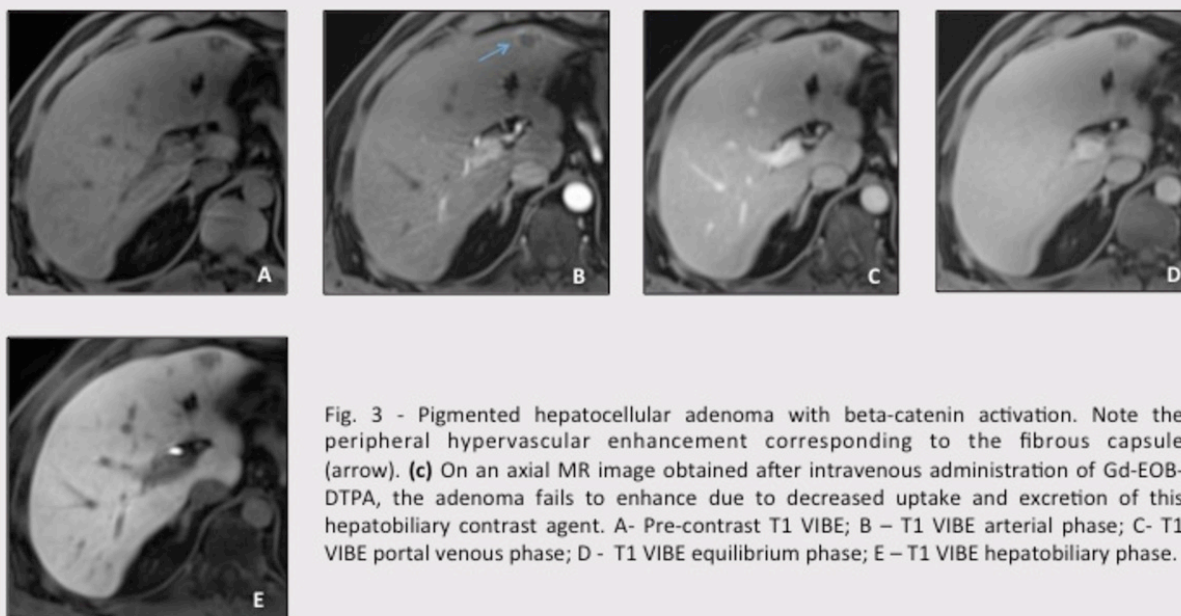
Pigmented hepatocellular adenoma with beta-catenin activation. Note the peripheral hypervascular enhancement corresponding to the fibrous capsule (arrow). (c) On an axial MR image obtained after intravenous administration of Gd-EOB-DTPA, the adenoma fails to enhance due to decreased uptake and excretion of this hepatobiliary contrast agent. A- Pre-contrast T1 VIBE; B - T1 VIBE arterial phase; C- T1 VIBE portal venous phase; D - T1 VIBE equilibrium phase; E - T1 VIBE hepatobiliary phase.
